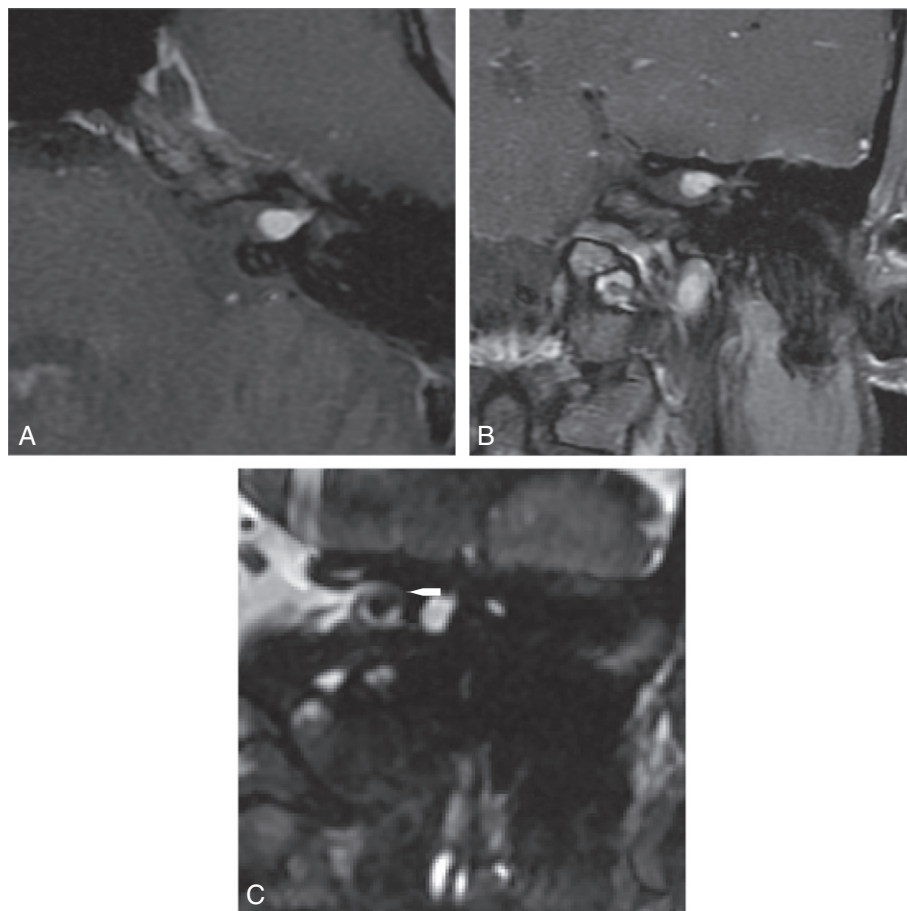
MRI imaging: (A) Post contrast T1-weighted axial image demonstrates a heterogeneously enhancing mass within the left internal auditory canal (IAC) extending to the fundus of the IAC. (B) Post contrast T1-weighted coronal image with fat suppression demonstrates that the IAC mass lies superior to the vestibular crest. (C) 3D-constructive interference in the steady state (CISS) coronal image on the left side also demonstrates marked thinning (white arrow) or absence of bone of the roof of the superior semicircular canal.
